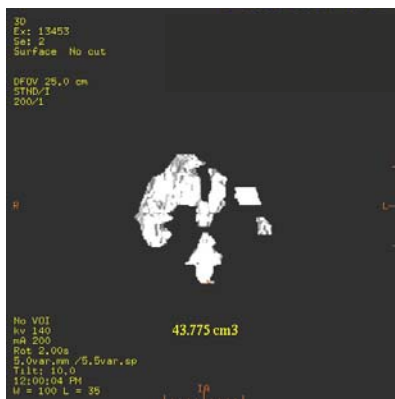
Intraventricular blood volume calculated by the volume analysis technique on CT scan.
